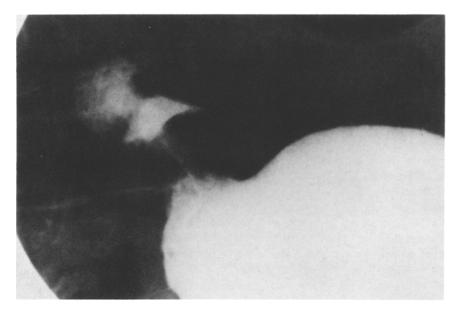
Radiograph of a 70-year-old woman with severe vomiting shows gastric outlet obstruction with minimal passage of barium contrast material through an elongated pylorus and a "shoulder" deformity of the lesser curve of the antrum mimicking hypertrophic pyloric stenosis. Surgical resection of the distal stomach revealed ectopic pancreas with pancreatitis
